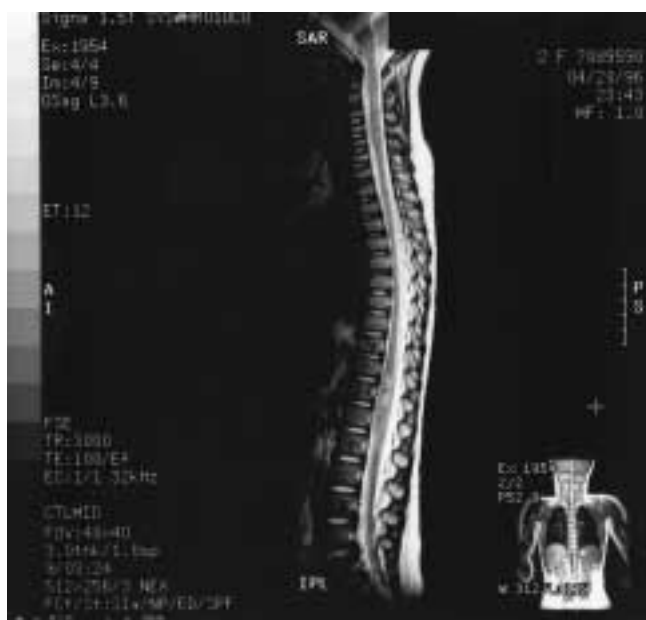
MRI of the spinal cord demonstrating decreased uptake (T1-weighted images) in the T11-T12 region.
